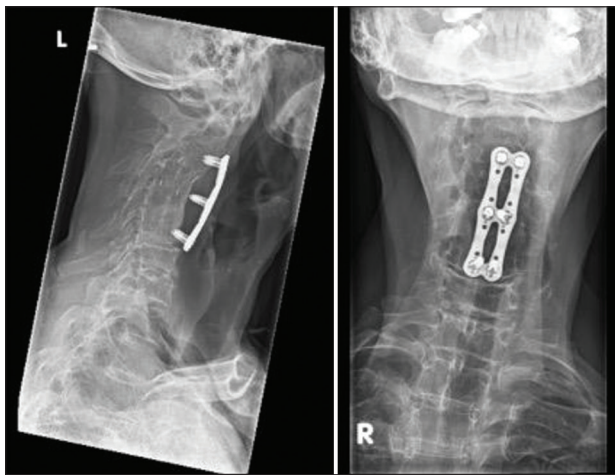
Neck X-rays 5 years after initial surgery showing unchanged position of anterior cervical discectomy and fusion. Fusion of C2/3/4/5/6 with focal kyphosis at these levels. Unchanged alignment of the cervical spine. No acute bony injury. Increased degenerative change with new osteophytosis of C6/7
